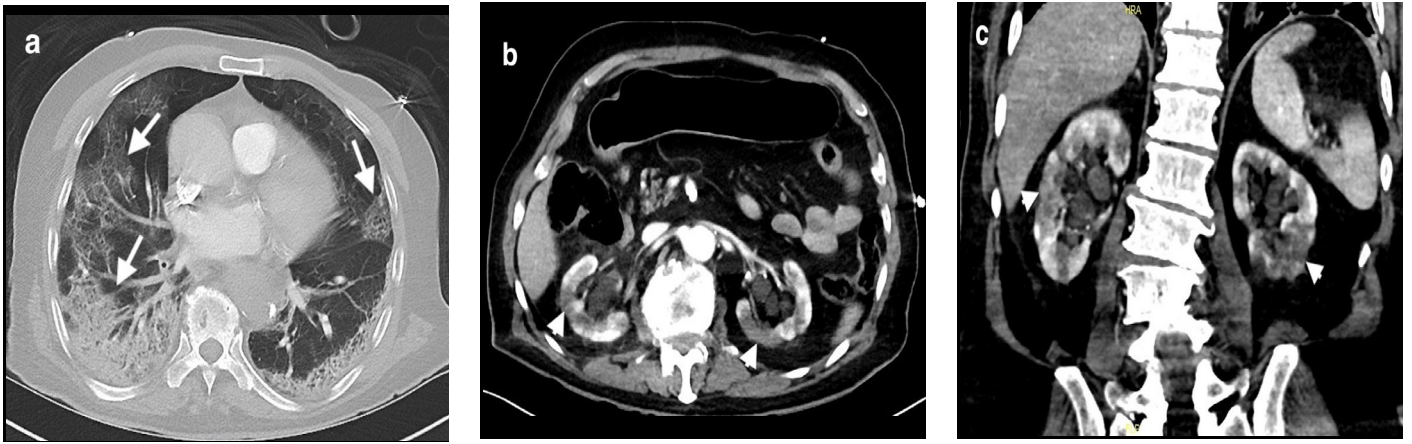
Renal infarct. (a) Axial chest computed tomography (CT) image showing bilateral ground-glass density and consolidations (arrows) in the peripheral portions of the lungs. Axial (b) and coronal (c) CT images reveal focal unenhanced areas (arrowheads) in the renal parenchyma, representing renal infarcts.
